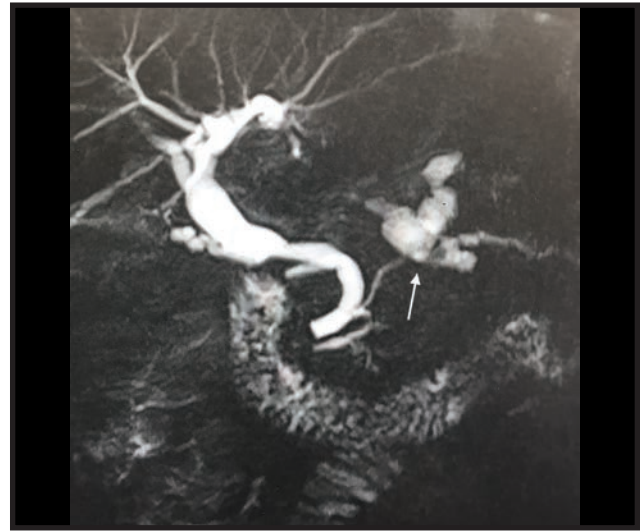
MRI demonstrating contrast extravasation (arrow)
